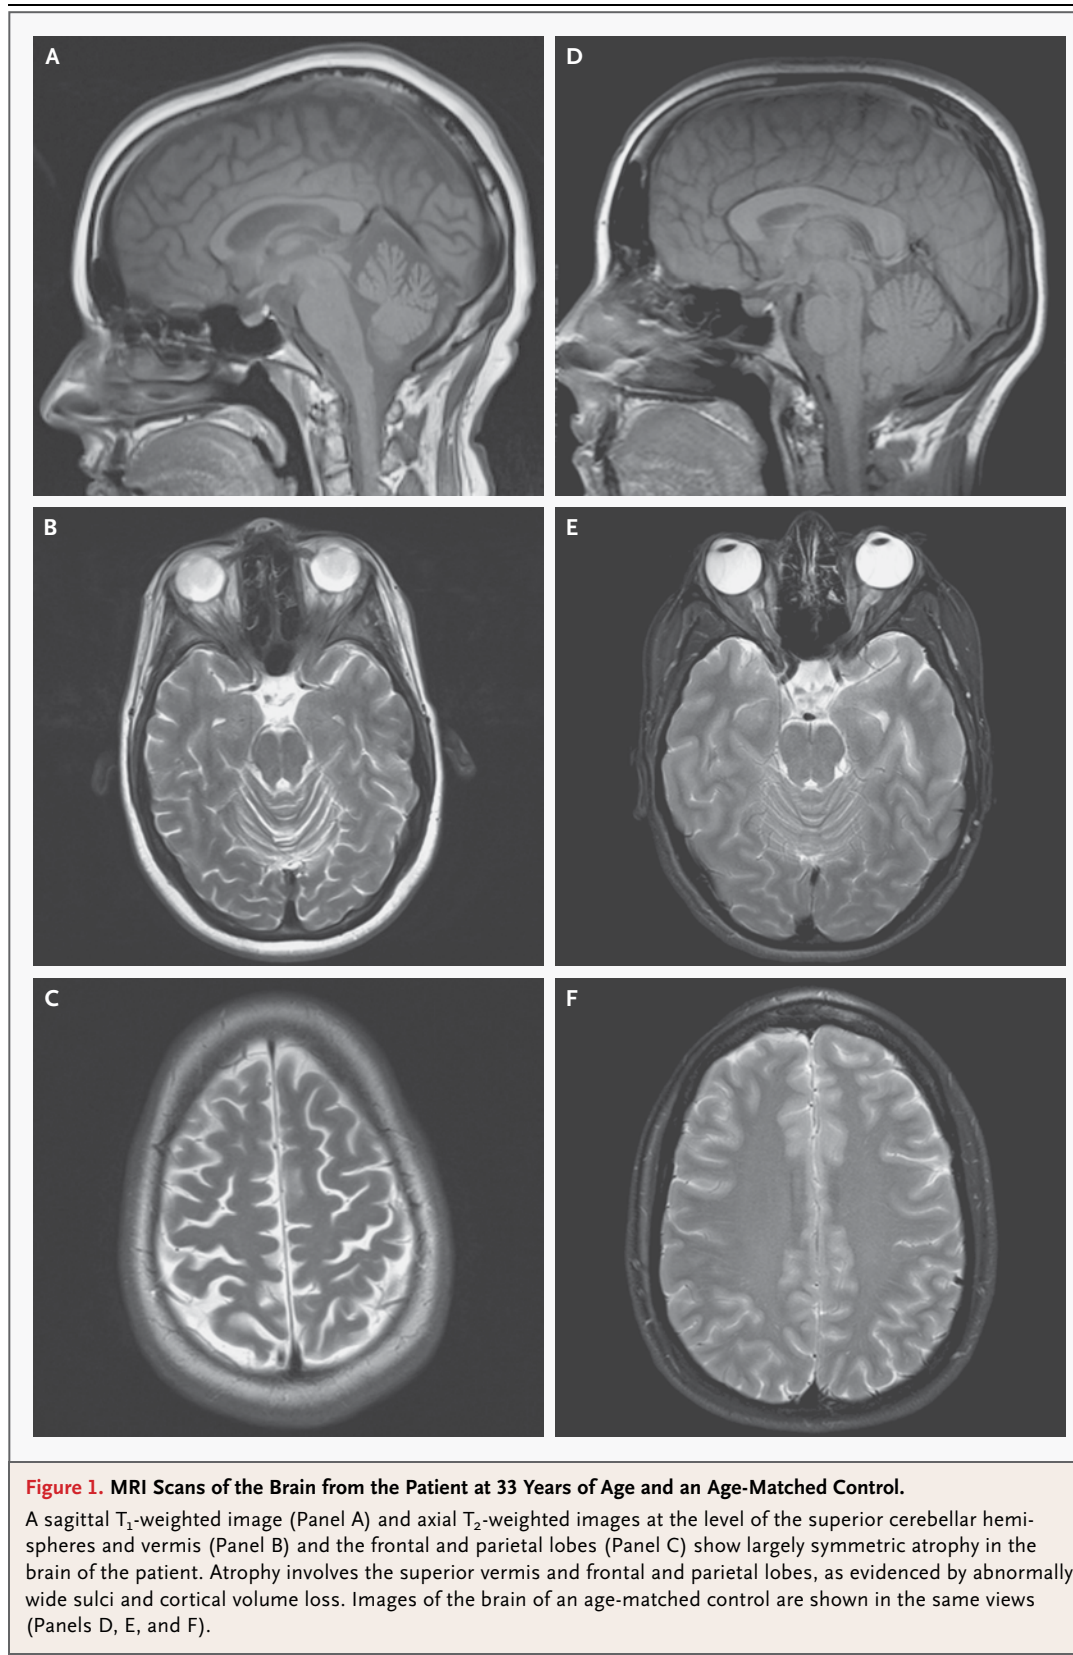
MRI Scans of the Brain from the Patient at 33 Years of Age and an Age-Matched Control.
